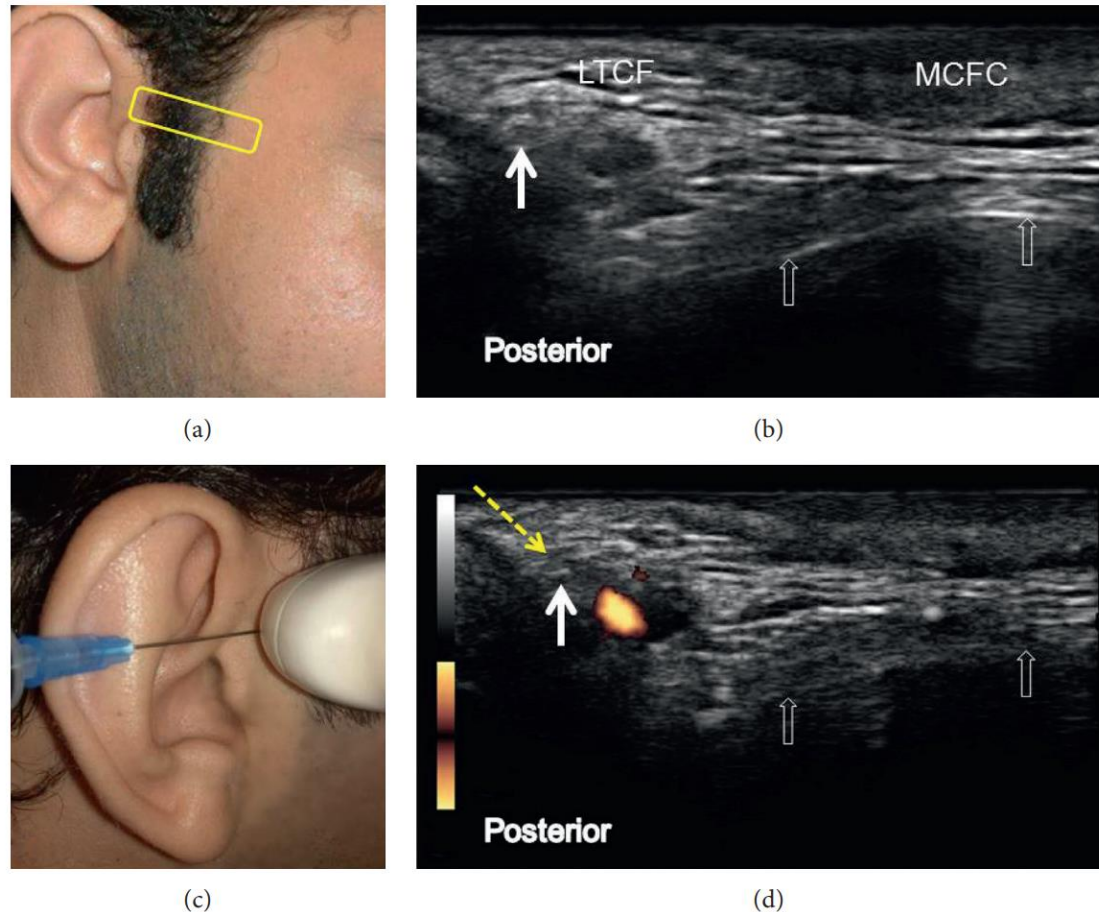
Sonoanatomy and ultrasound-guided injection technique for the auriculotemporal nerve: (a) the transducer position (yellow rectangle), (b) ultrasound imaging of the auriculotemporal nerve (white solid arrow), (c) introducing the needle in the posterior-to-anterior direction using the in-plane approach to target the auriculotemporal nerve, and (d) the power Doppler image of the superficial temporal artery. The empty white arrows denote the zygomatic arch. The yellow dashed arrow indicates the needle trajectory. MCFC: middle cheek fat compartment and LTCF: lateral temporal cheek fat. All the pictures were obtained from the face of the first author.
